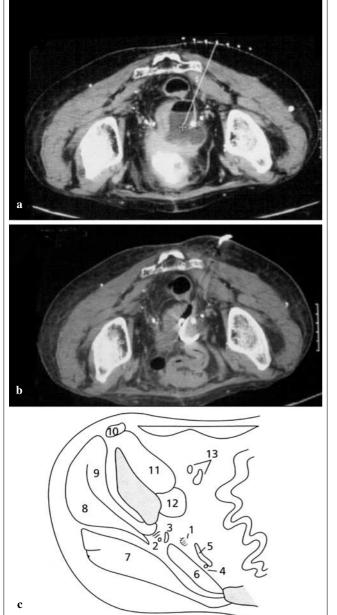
Direct trocar technique.* a Axial CT image of a deep multiloculated abscess within the bowel loops. The presence of bowel loops precluded a direct anterior approach, preferring a lateral trans-abdominal access route. The direct trocar technique was chosen to drain the collection. b The assembled catheter (needle-stylet + metal stiffener + plastic catheter) was inserted directly into the abscess cavity
